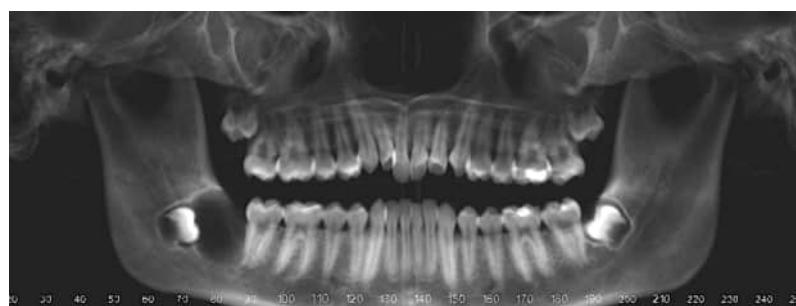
CBCT reconstructed panoramic film. Dentigerous cyst associated with unerupted tooth #32.
